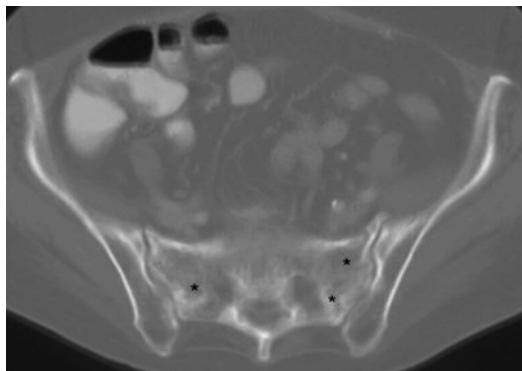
Sacral insufficiency fractures. Coronal CT bone window shows bilateral insufficiency ill-defined fractures (*) difficult to characterize with this imaging technique
